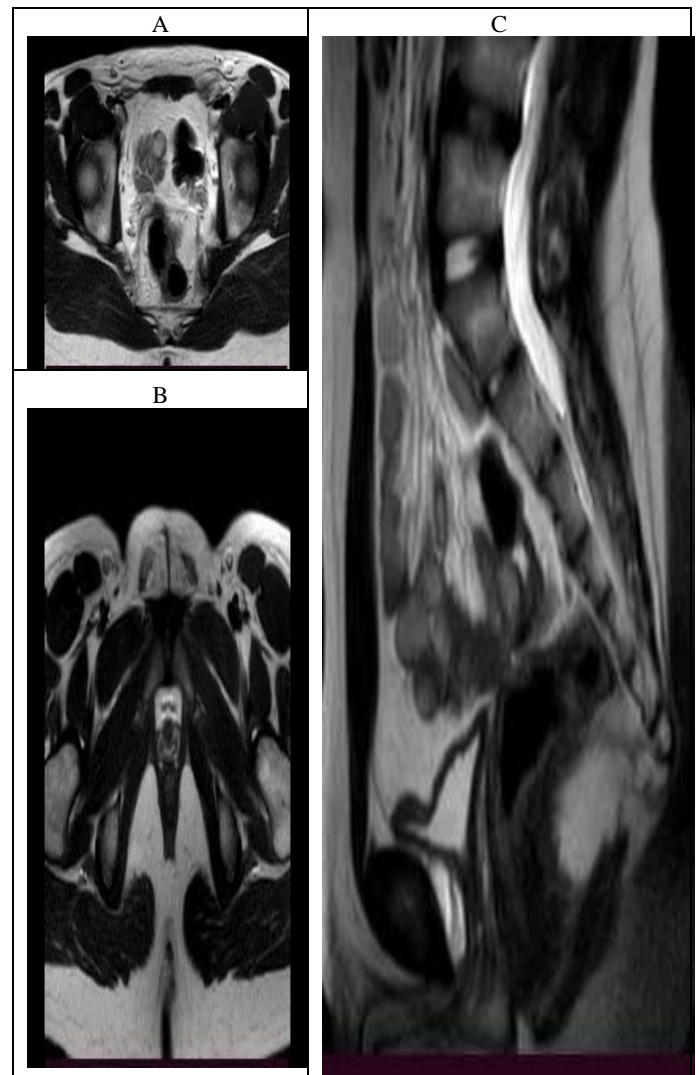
Pelvic MRI: T2 WI (A and B) axial cut and (C) sagittal cut. they show the absence of uterus, cervix and both ovaries with the presence of proximal vaginal canal.
